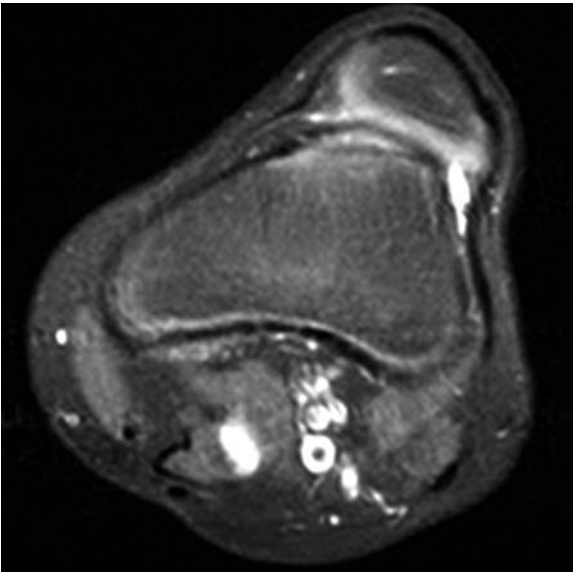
Patellofemoral dysplasia. Axial proton density fat suppressed MR image through the proximal part of a dysplastic convex trochlear 'groove'
